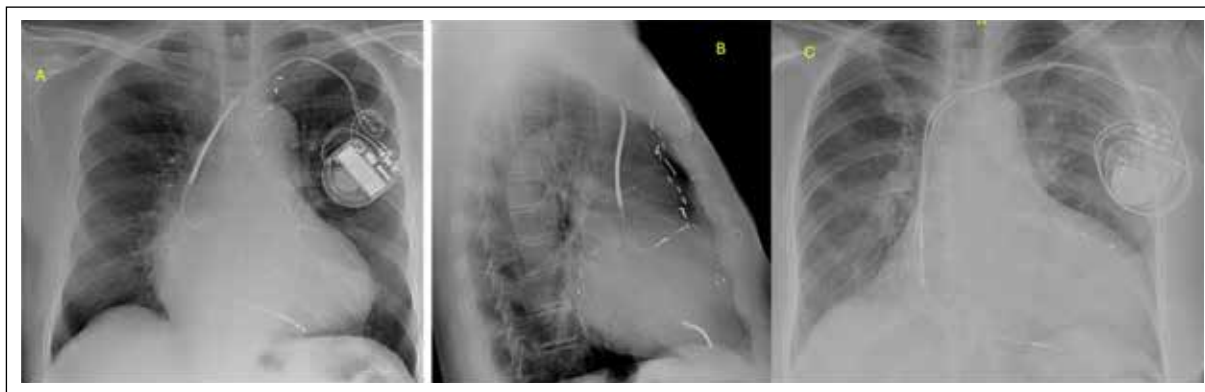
Images show lead positions in a patient with dual chamber dual coil CRT-D in frontal (A) and lateral chest radiographs(B). Note the defibrillator lead is positioned in the apical RV septum. The RA lead in the lateral film shows an L / open "V" configuration, indicating the lead is pulled up due to less loop while fixing the lead. An optimal loop of RA lead should look like the letter "U". Another patient (C) with bipolar CRT-P device insitu.
